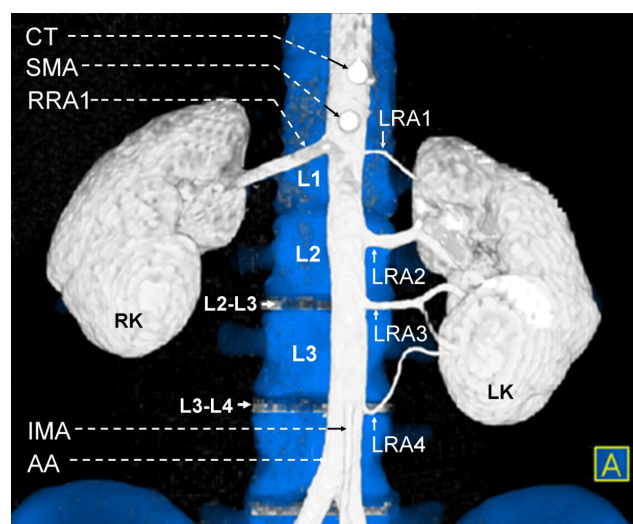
Coronal image with the highlight of the kidneys and AA on MDCT angiographies with 3D reconstruction. Coronal VRT image with the origins of the RAs from the AA, and their relationship to vertebral bodies. AA: Abdominal part of aorta; MDCT: Multidetector computed tomography; 3D: Three-dimensional; VRT: Volume rendering technique; RAs: Renal arteries; RK: Right kidney; LK: Left kidney; RRA1: First right renal artery (right main renal artery); LRA1: First left renal artery (polar superior renal artery – AdRA); LRA2: Second left renal artery (left main renal artery); LRA3: Third left renal artery (middle-inferior renal artery – AdRA); LRA4: Fourth left renal artery (polar inferior renal artery – AdRA); AdRA: Additional renal artery; CT: Celiac trunk; SMA: Superior mesenteric artery; IMA: Inferior mesenteric artery.
